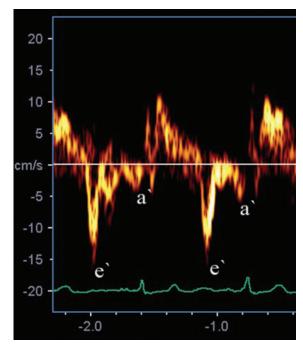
Lateral tricuspid annulus tissue Doppler demonstrates both an early diastolic velocity (e') and late diastolic velocity (a').
